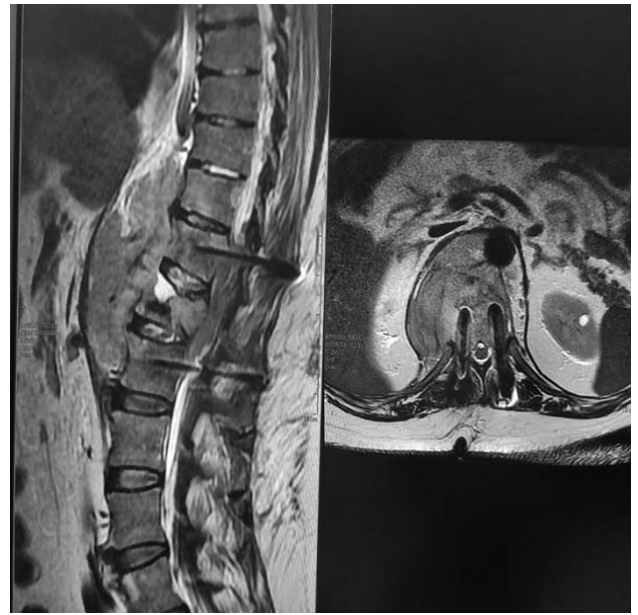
MRI T2W images showing vertebral lymphoma with large para spinal soft tissue mass.
